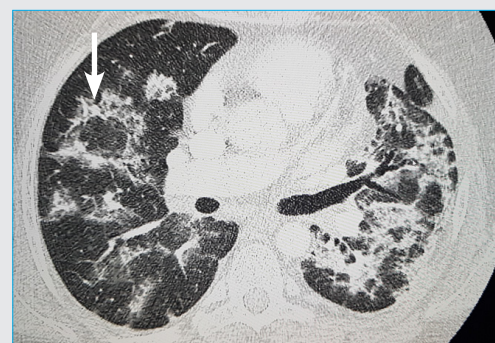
Cross section chest CT scan below the bifurcation of trachea of a patient with COVID-19 shows bilateral opacifications, round and irregular, typical of organizing pneumonia, located at perilobular and peripheral areas. The arrow points to the reverse halo signs (atoll sign); A central lucency surrounded by an opacity.
